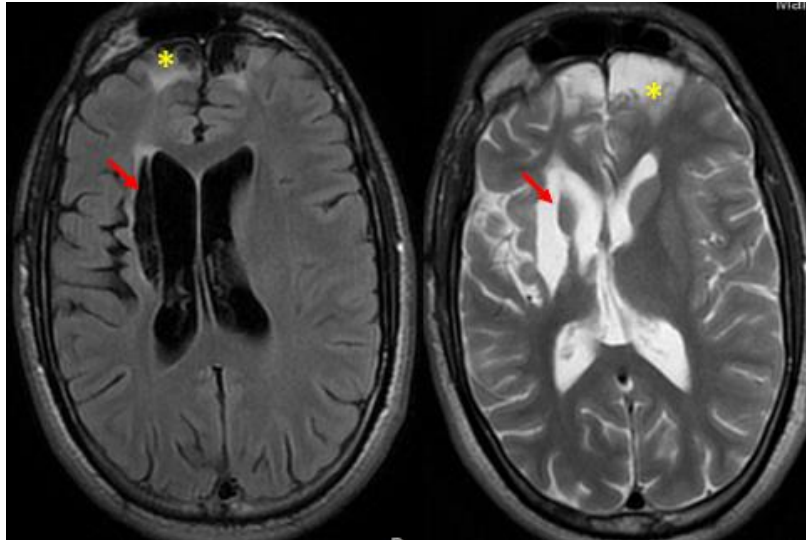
Brain MRI in axial T2 and Flair séquences revealing a right capsulo-lenticular porencephalic cavity, characterized by hypointensity on T1-weighted images and pronounced hyperintensity on T2-weighted images that diminished on FLAIR sequence (red arrows). This cavity resulted in the displacement of the ipsilateral lateral ventricle and dilation of cortical sulci adjacent to it indicative of post ischemic sequelae. In addition, bilateral frontal gliosis lesions were observed, showing hyperintensity on FLAIR images. These lesions exhibited hemorrhagic stigmata on the gradient-echo T2 sequence, indicative of post-traumatic sequelae (yellow asterix)
